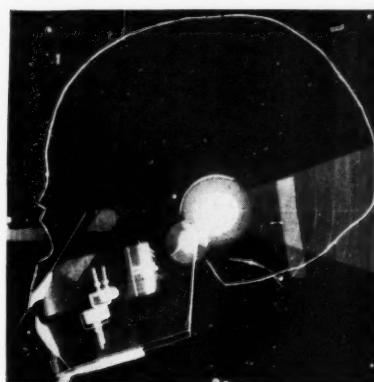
Head film made from perspex skull mounted in the cephalometer and radiographed.
